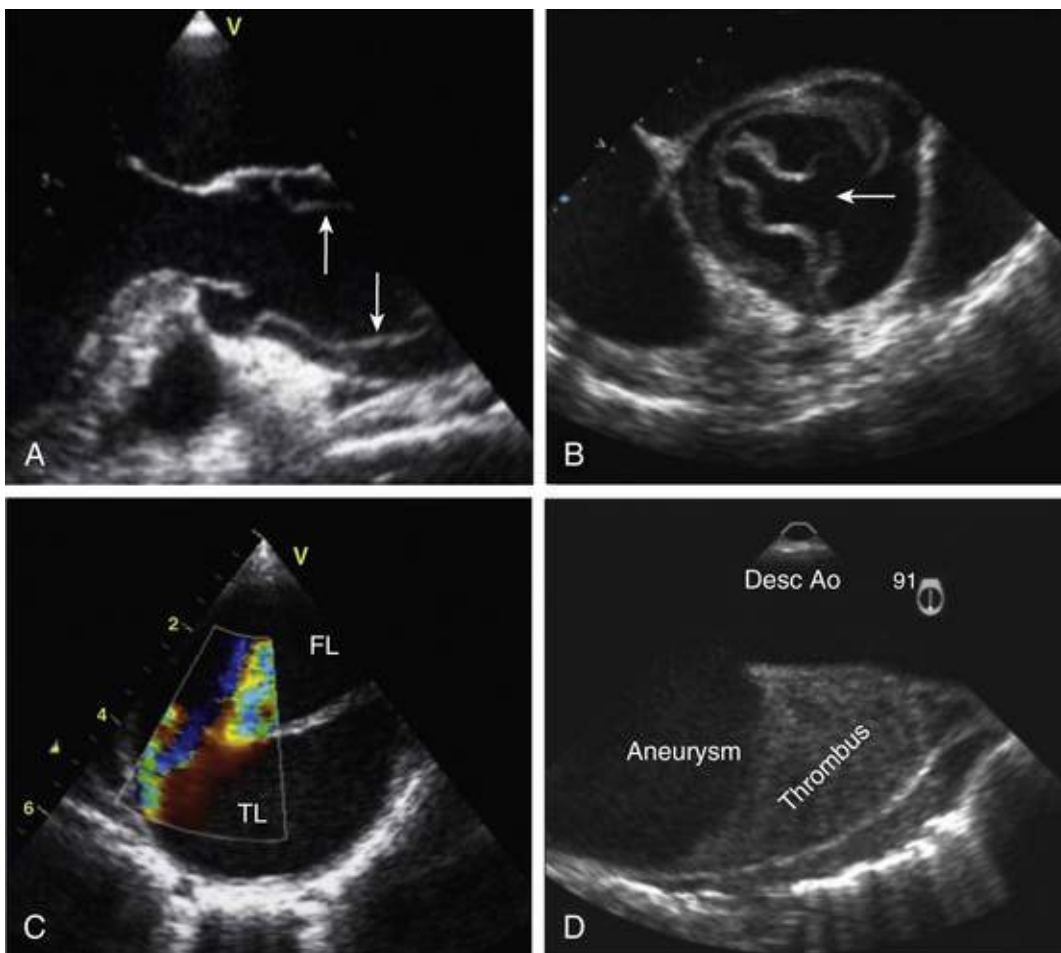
Transesophageal echocardiographic assessment of thoracic aortic disease. Acute type A dissection visualized in longitudinal and short-axis views; *arrows* indicate dissection lamella (A) and an intimal tear close to the aortic leaflets (B). C, Color flow mapping in a patient with chronic type B dissection shows vigorous flow into the false lumen (*FL*), demonstrating the communication between true lumen (*TL*) and *FL*. D, Partial thrombosis in aneurysmal *FL* in chronic type B dissection. (From Baliga RB, Nienaber CA, Bossone E, et al. The role of imaging in aortic dissection and related syndromes. *JACC Cardiovasc Imaging* 2014;7:406-24.)
